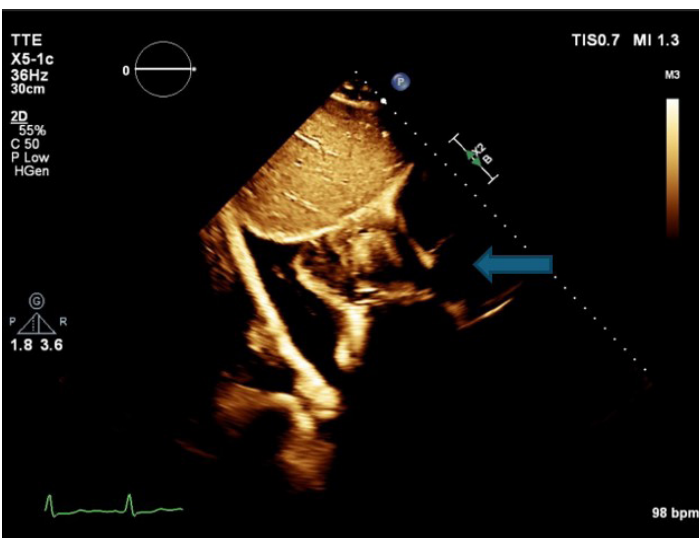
Transthoracic Echocardiogram showing the heart and a well-defined extracardiac cystic mass compressing the right atrium. Doppler flow signals were detected within the cyst, raising suspicion of a congenital heart defect. Arrow pointing at the tumor.
